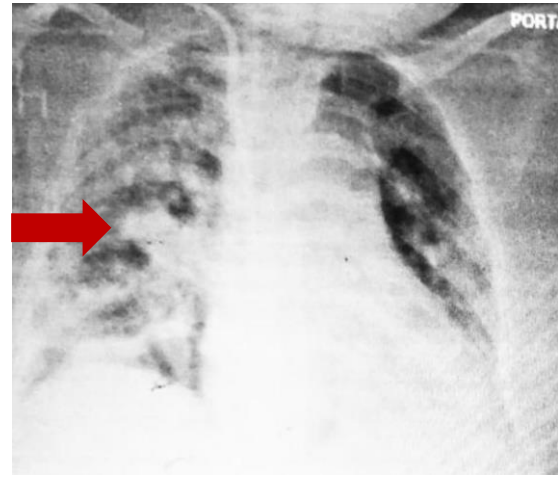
Portable X-ray Chest AP view of the same pt done 2 days later showing worsening of radiological picture (diffuse non-homogenous opacities).
